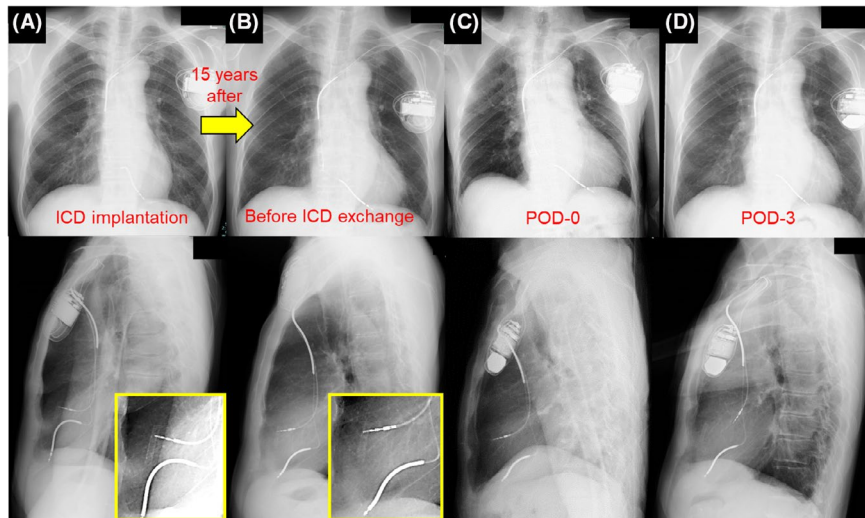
Chest X-rays from left to right: at 7 d after the original ICD implantation (A) and before (B), immediately after (C), and at 3 d after (D) ICD exchange. The upper and lower panels show frontal and lateral views, respectively. The chest X-rays immediately after ICD replacement were recorded in the supine position, while the others were recorded in the erect position. Although the chest X-ray immediately after ICD exchange shows no apparent atrial lead dislocation, the atrial lead had moved away from the right atrial wall within 3 d after the operation. Based on the positions of the tip of the atrial lead and coronary stent in the lateral images, the tip of the atrial lead had not moved over the previous 15 y. POD, postoperative day
